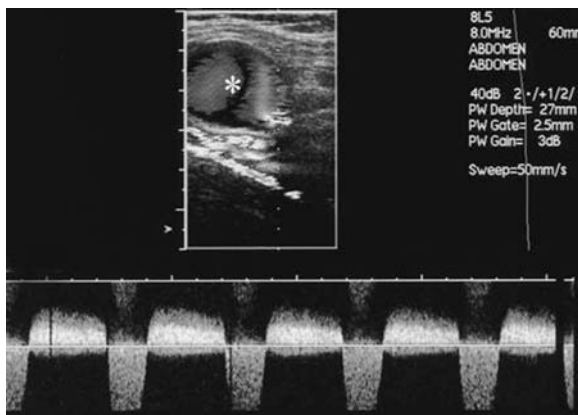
Color Doppler ultrasound of the groin shows a pseudoaneurysm (*asterisk*) with a diameter of 2 cm and color flow centrally in the pseudoaneurysmal cavity. Duplex scanning of the pseudoaneurysmal neck demonstrates a typical to-and-fro signal
